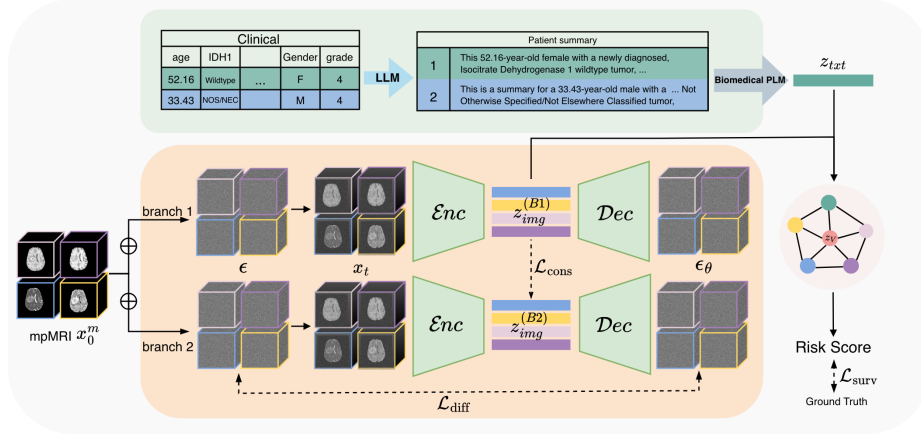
Overview of the proposed multimodal survival framework. Structured clinical data are converted into text summaries and encoded via a biomedical PLM (z_{txt}). Multi-parametric MRI volumes (x_0^m) are processed through a dual-branch diffusion encoder under stochastic perturbations (x_t). The shared 3D U-Net is optimized using a noise-prediction loss ($\mathcal{L}_{\text{diff}}$) and a stop-gradient consistency loss ($\mathcal{L}_{\text{cons}}$). The resulting image and text embeddings are integrated via a virtual-node attention graph to predict risk scores ($\mathcal{L}_{\text{surv}}$).
